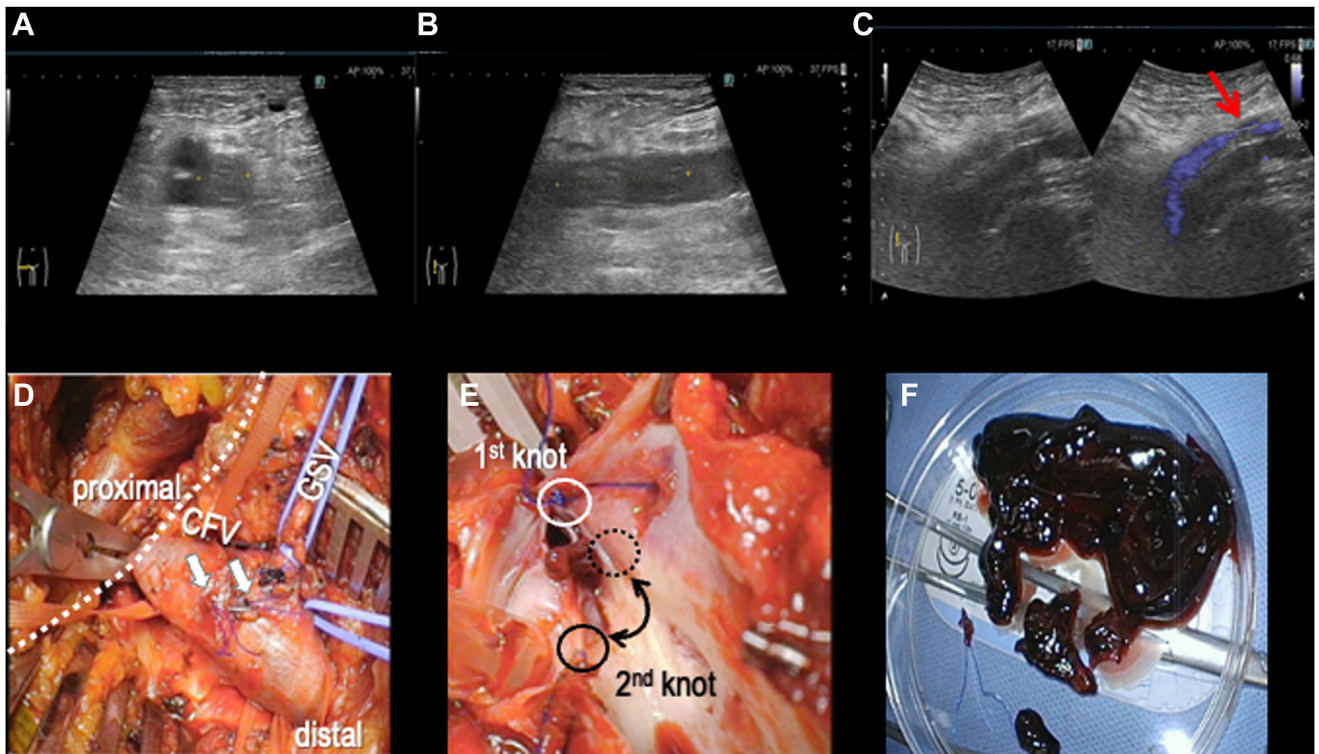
A–C: Ultrasonography of the femoral vein near the puncture sites. The cross-sectional image at the portion distal to the puncture site showed a smoke-like echo (A). In the long-axis view, the venous lumen was echolucent and noncompressible. Venous narrowing was not detected (B). Color Doppler imaging demonstrated a significant limitation of flow just proximal to the puncture site (red arrow) (C). D: Gross appearance of the right common femoral vein (proximally clamped) showed no evident stenosis. A white dashed line indicates the original position of the right inguinal ligament. Two of the 4 knots with long threads remained on the venous surface (white arrows). E: A longitudinal incision was made at the venous valve was bicuspid and 2 leaflets were sutured together by 2 threads. F: The venous lumen was filled with massive thrombi, which were removed manually. CFV = common femoral vein; GSV = great saphenous vein.
